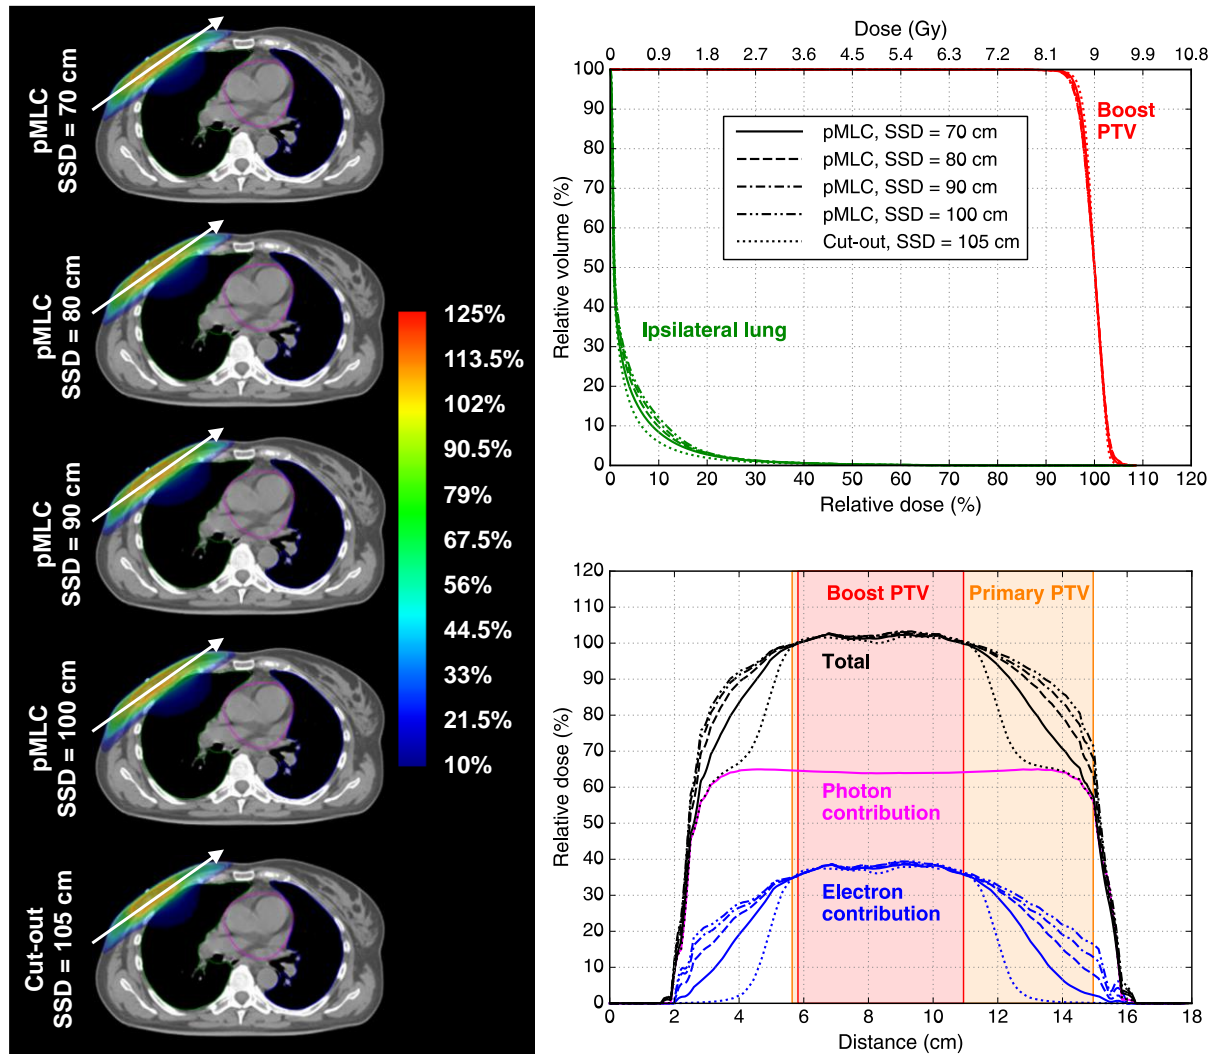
Dose distributions (left) and DVHs (top right) of TrueBeam 6 MeV 1E2X plans created for the right breast boost case and dose profiles (bottom right) indicated by a white arrow on the dose distributions. The legend of the DVHs also applies to the dose profiles. The contours of the boost PTV (red), primary PTV (orange), ipsilateral lung (green), contralateral lung (blue) and heart (magenta) are visible on the transversal CT images.
